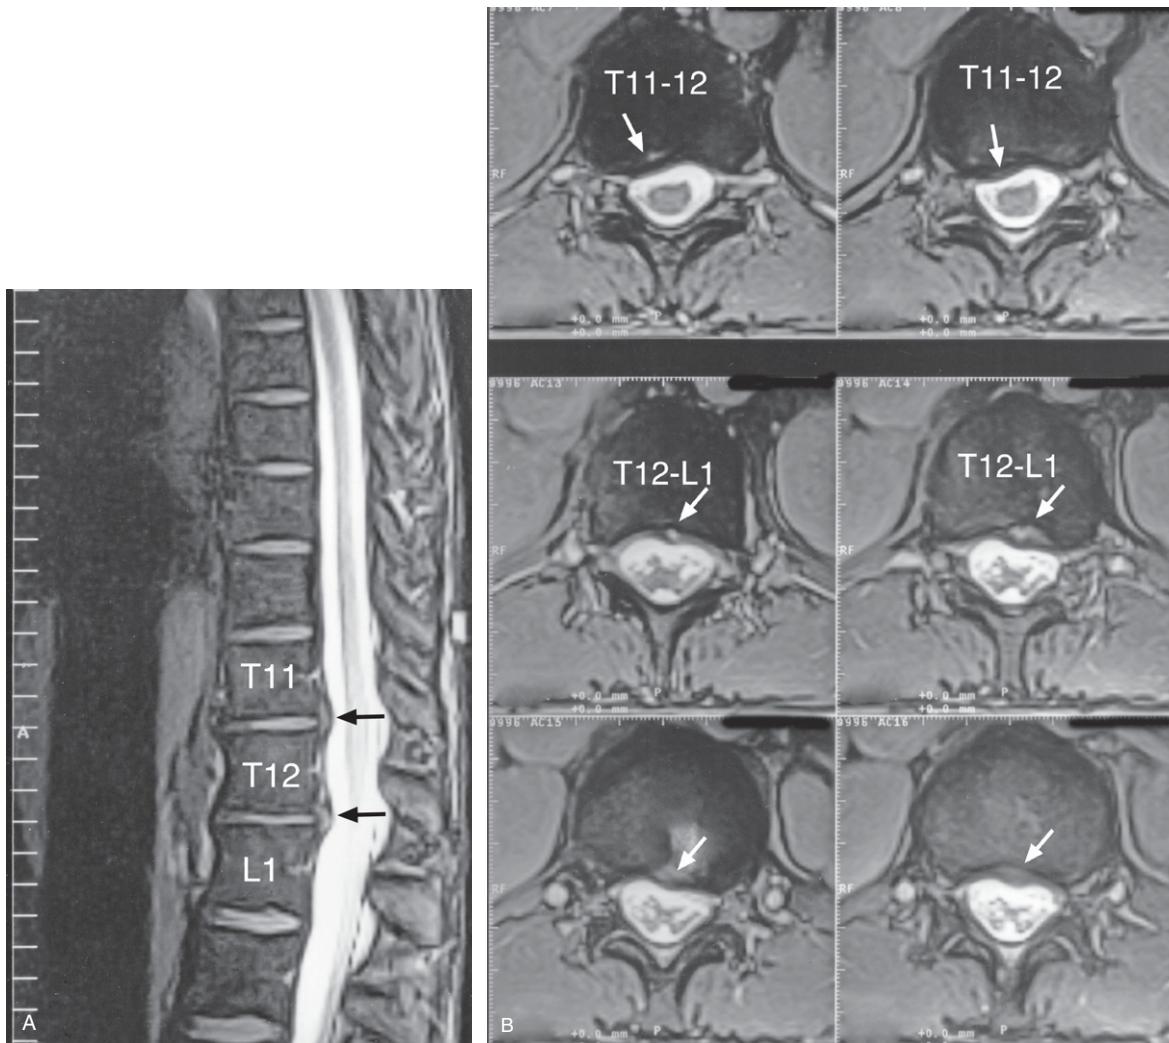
(A) MRI sagittal T2-weighted image showing narrowing and loss of signal of the T11-12 and T12-L1 intervertebral discs that have posterior disc protrusions (arrows) that indent the thecal sac. Axial views are shown in Fig 40.2B. (B) MRI axial T2-weighted images at the T11-12 and T12-L1 levels. Note (i) the central to right sided disc protrusions at T11-12 (arrows), and (ii) the central to left sided disc protrusion at T12-L1 (arrows).
